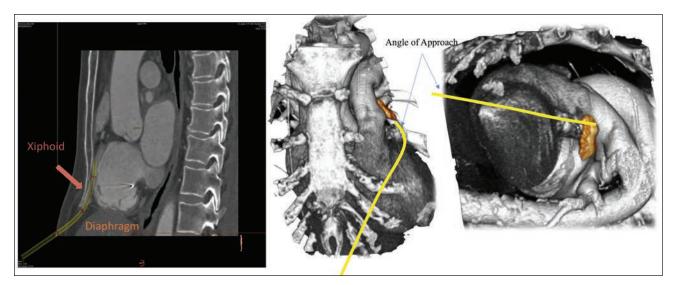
CT roadmap showing orientation of important structures and preferred angle of approach.
